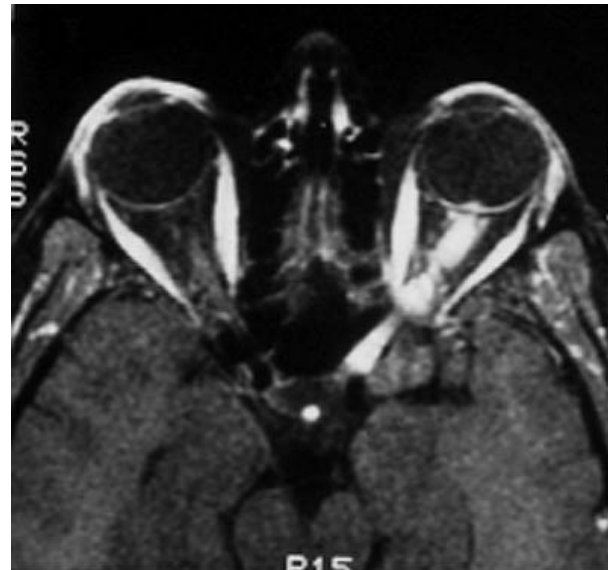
Typical MRI finding in one of our patients with optic neuritis.
